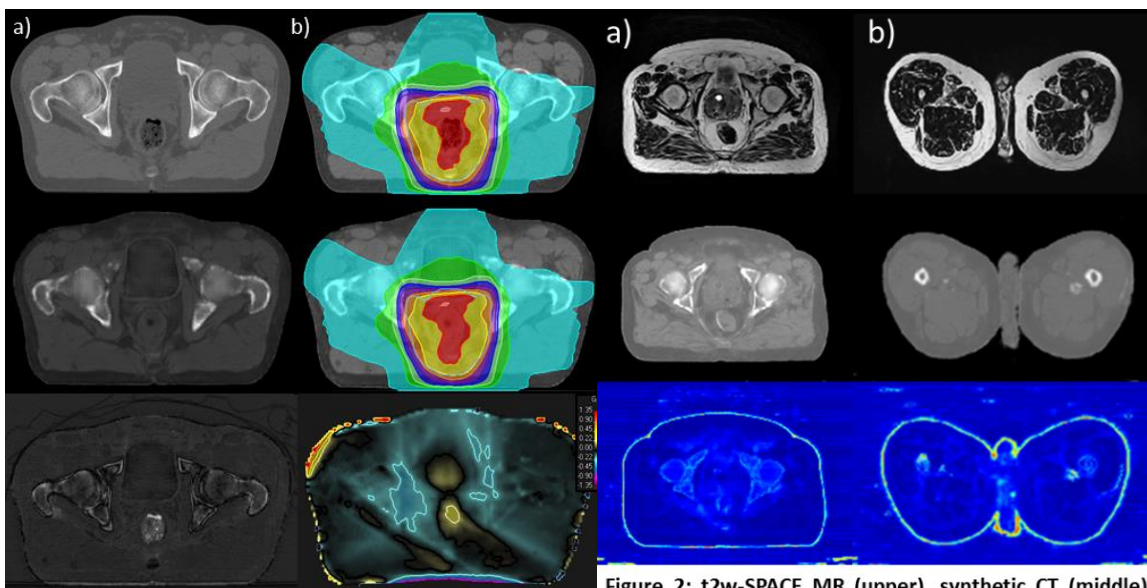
Planning CT (upper), synthetic CT (middle) and their differences (lower) in terms of a) HU and b) dose with a prescription dose of 45Gy. HU and dosimetric differences can be seen to be minimal, where light blue and yellow contours indicate dosimetric differences of  $\pm 0.5\%$ .
